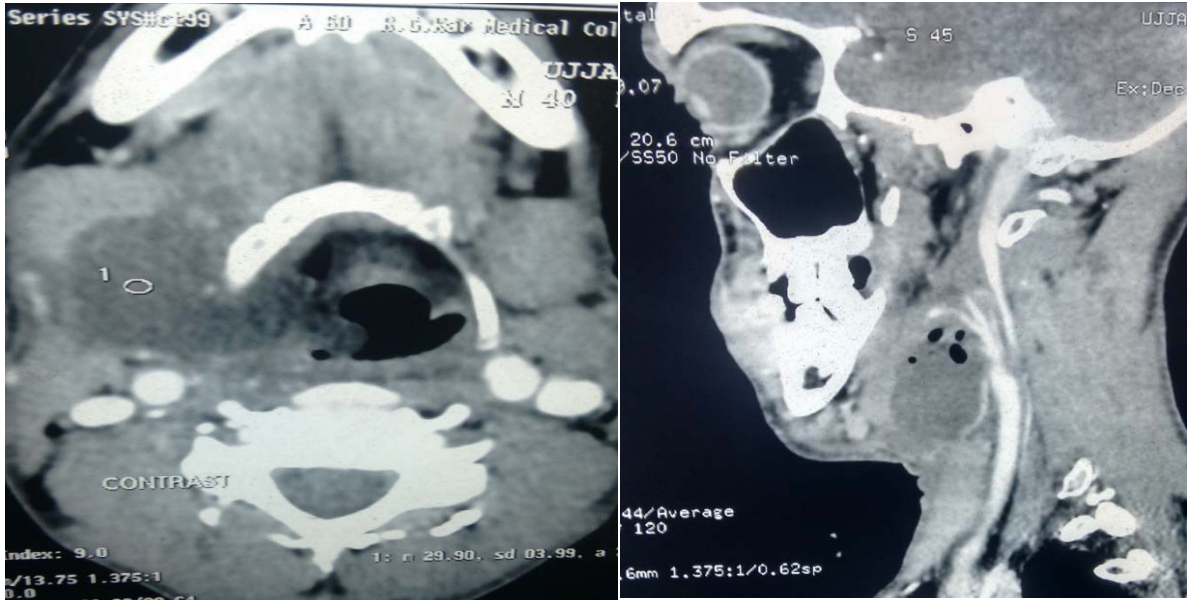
CT scan neck showing submandibular abscess
